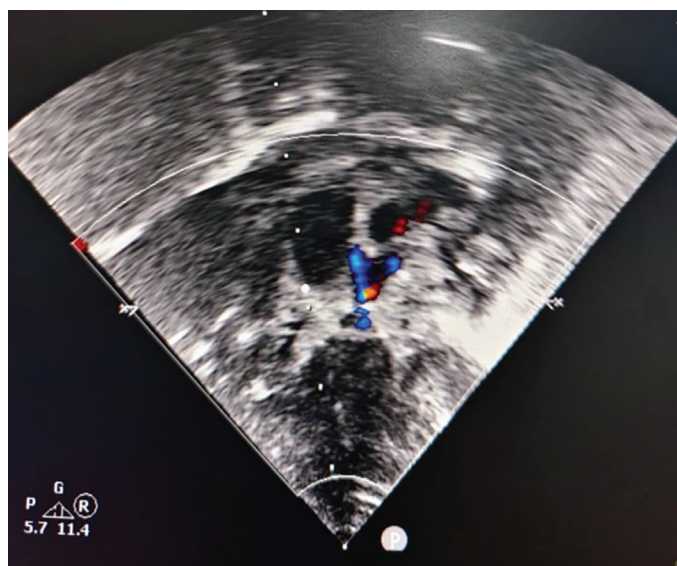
Postoperative echocardiography showing restored antegrade pulmonary blood flow, preserved left ventricular systolic function (ejection fraction 75%), persistent moderate tricuspid regurgitation, residual secundum atrial septal defect with bidirectional shunt and patent ductus arteriosus
